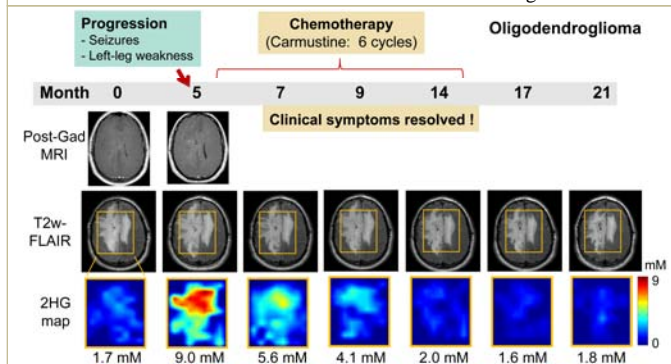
A diffuse oligodendroglioma responded rapidly and completely to chemotherapy. 2HG was highly correlated with progression and treatment effects, while post-gadolinium MRI and T2w-FLAIR did not show noticeable changes.
